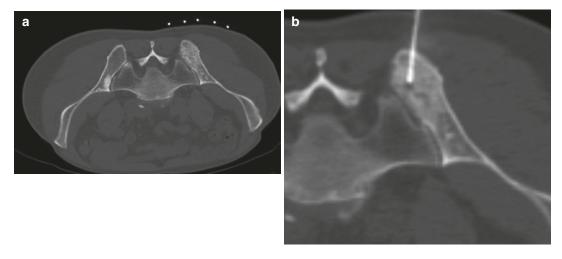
A 68-year-old male with right pelvic pain. (a) Axial CT with patient prone demonstrates ill-defined sclerotic lesion of the right posterior ilium and (b) CT-guided
